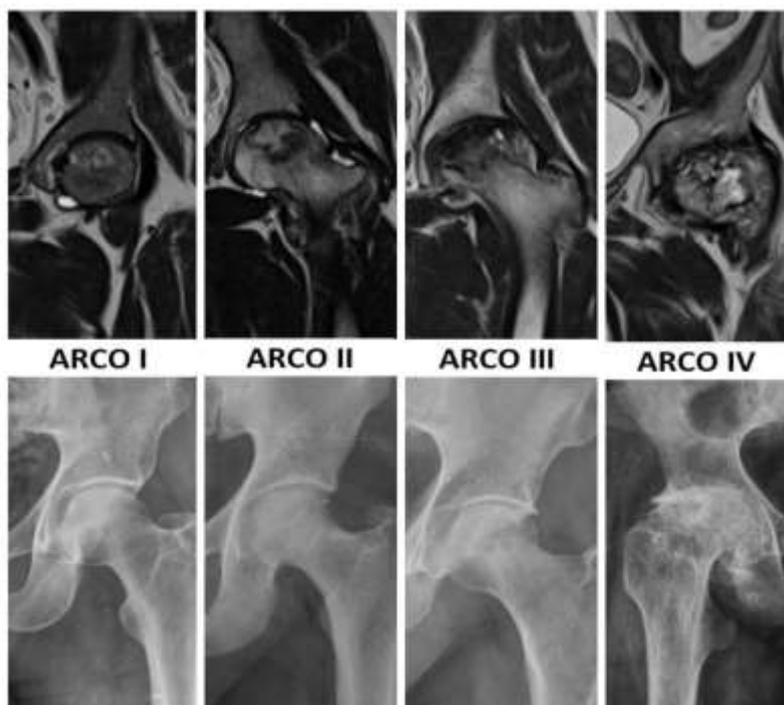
Various stages of ONFH on MRI and radiographs
